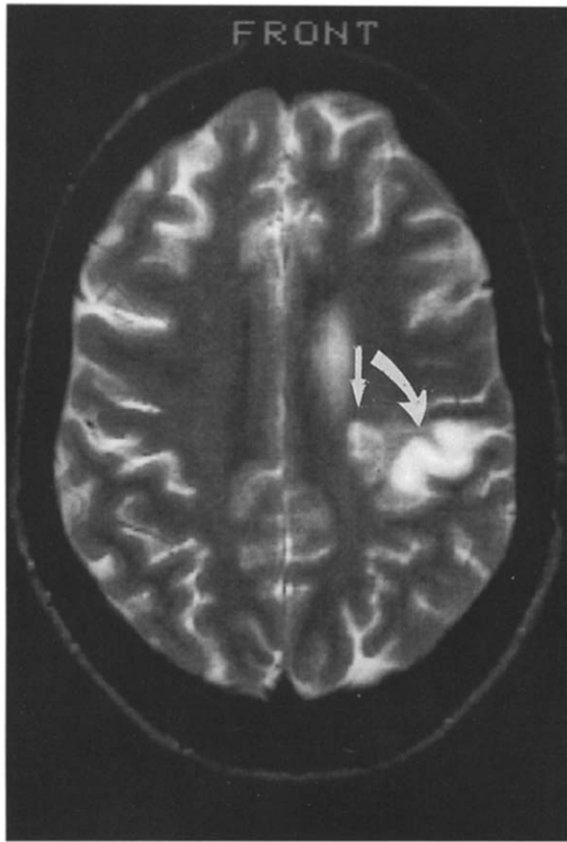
T<sub>2</sub>-weighted axial MRI (T<sub>R</sub> = 2,800, T<sub>E</sub> = 90) showing a high-intensity signal lesion in the left parietal cortex (→) with slight edema (→) in the adjacent subcortical white matter (R = right, L = left).
